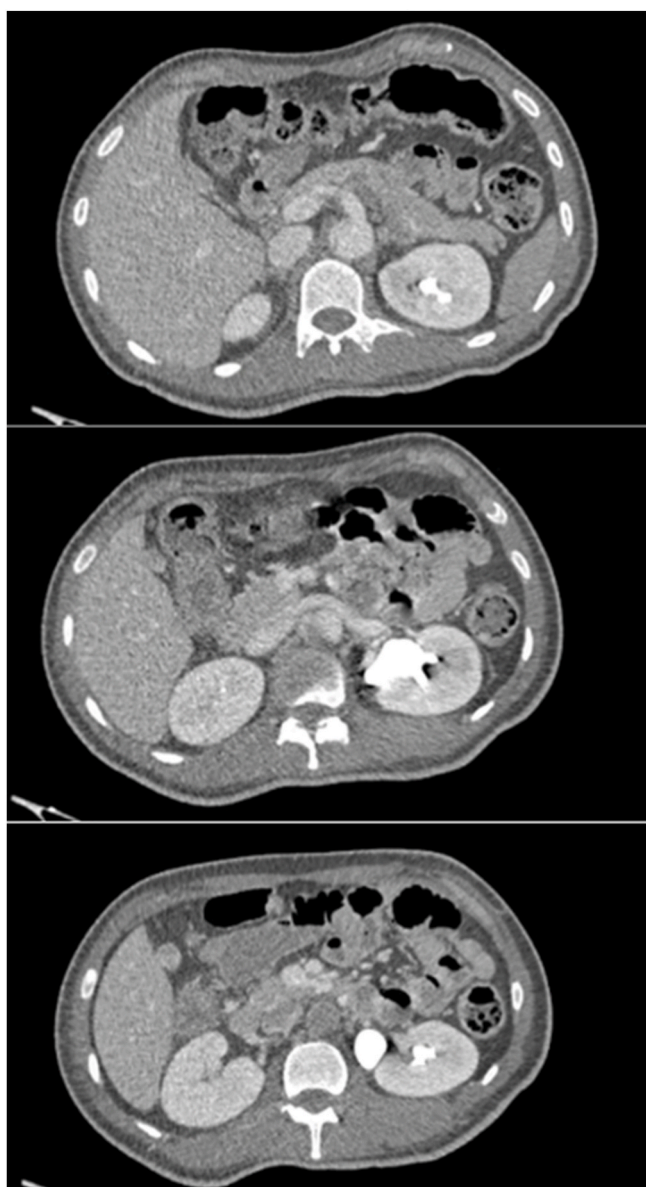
CT-Scan of the patient showed dissection from the aortic arch to the abdominal aorta about 2 cm above the common iliac bifurcation, and proximal a. superior mesenteric (Stanford B, DeBakey III), with an intimal tear (inlet) at the level of the aortic arch about 2.3 cm distal to the branch of the left subclavian artery and thrombus in the false lumen of the abdominal aorta at infrarenal level causing occlusion of the distal abdominal aorta.
